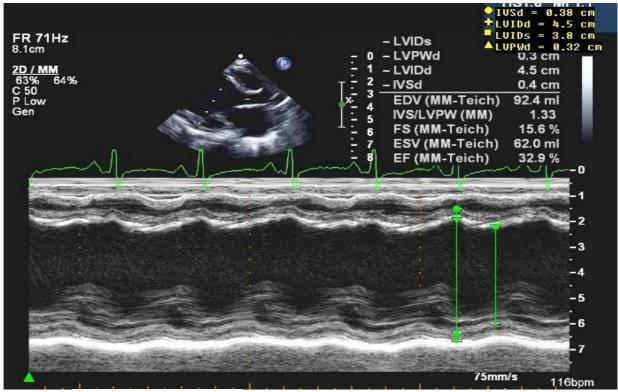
Preoperative echocardiography showed dilated cardiomyopathy with depressed left ventricular systolic function
